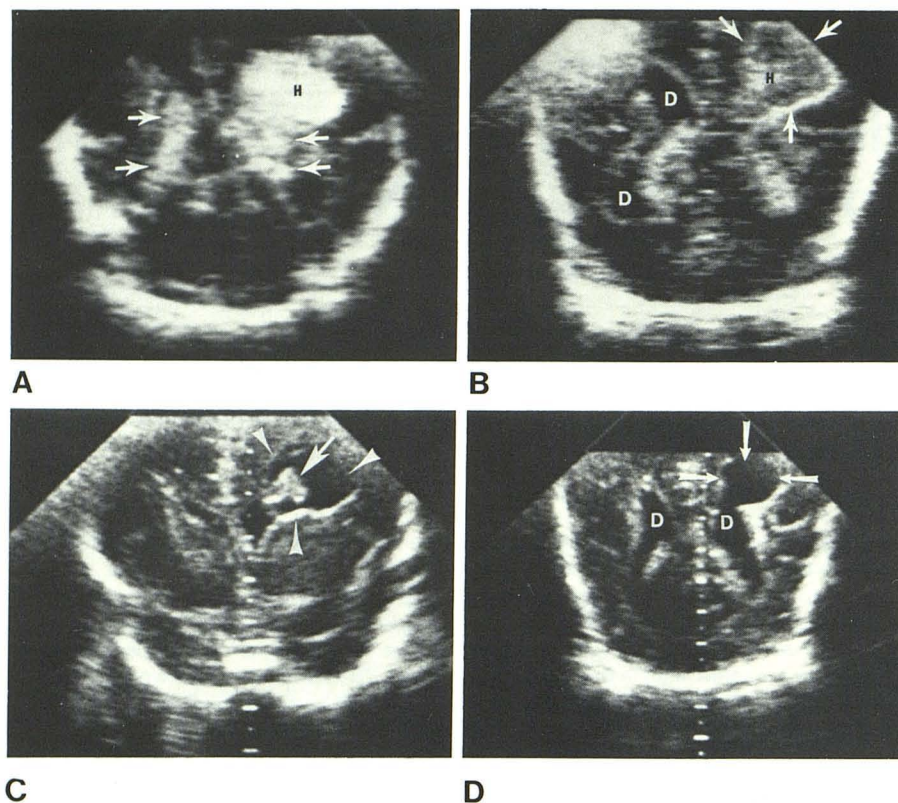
Evolution of porencephalic cyst. A, Coronal sonogram at 4 days of age. Intensely echogenic area in left frontoparietal region (H) represents intraparenchymal hemorrhage. Note continuity with intraventricular hemorrhage (arrows). B, "Rind" phase at 2 weeks. Echogenic border (arrows) now surrounds relatively hypoechoic center (H). Mild ventricular dilatation (D) on right. C, "Clot retraction" at 3 weeks. Porencephalic cyst (arrowheads) with small amount of echogenic clot remaining (arrows). D, 5 weeks of age. Mature porencephalic cyst (arrows) and moderately enlarged ventricles (D).
